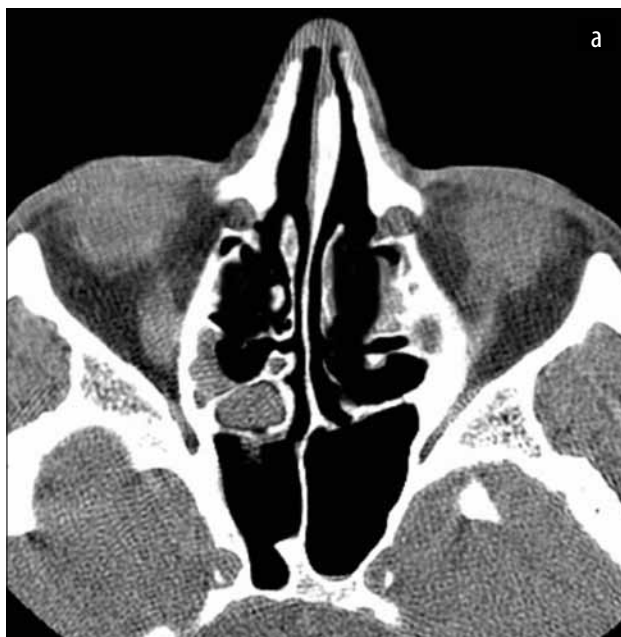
Cranio-facial CT scan, axial (a) and coronal (b) slices - residual Onodi cell or posterior ethmoid cell
